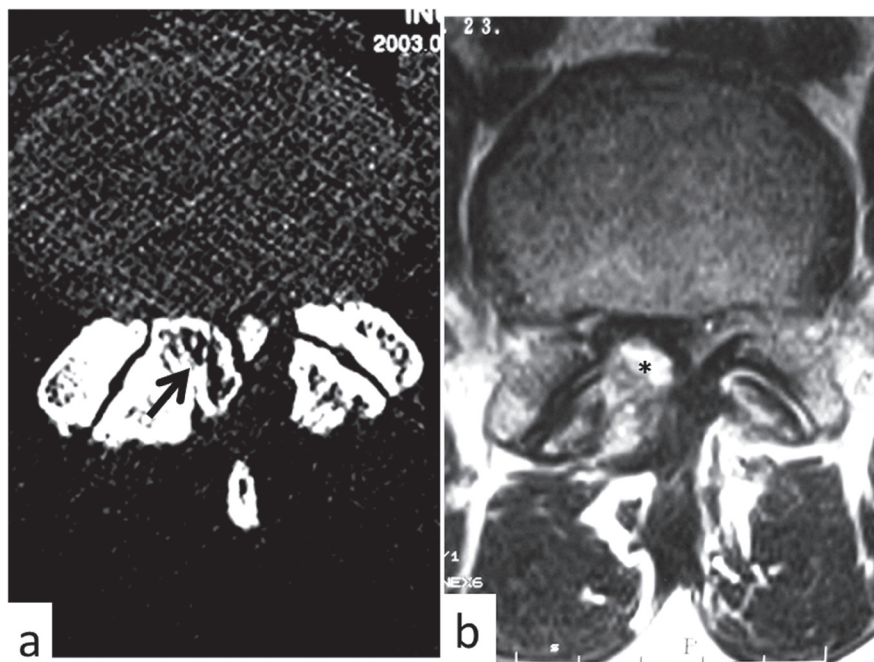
(Patient 1) Computed tomography after myelography showed a bony tumor (arrow) with cortical and medullary continuity with inferior articular process of the right L4 vertebra (a). The lesion contained central cancellous bone (asterisk) displaying high signal intensity in T₂-weighted image (b).
